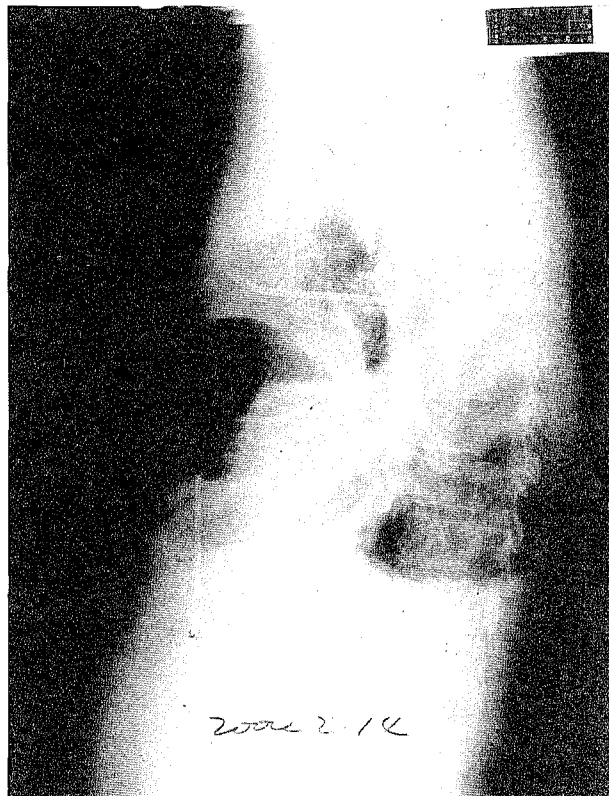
Chest roentgenogram with a left lateral view shows the homogenous infiltration with the air-fluid level in the anterior mediastinum
